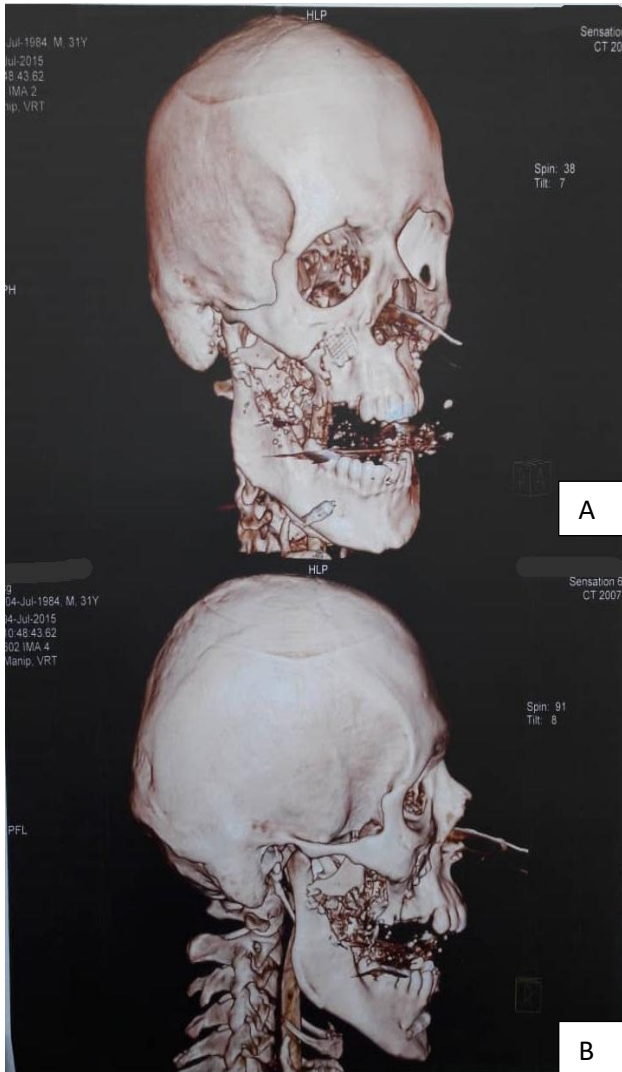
(A and B): Three-dimensional CT reconstruction showing asymmetrical maxillary reduction and misplaced fixation hardware following the initial surgery.
